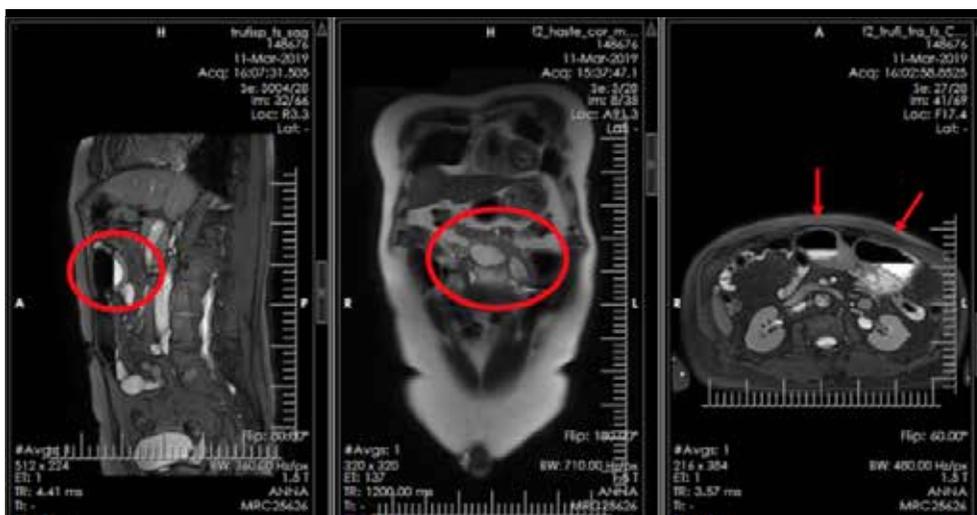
MRI images in lateral view, coronal view and sagittal view.
